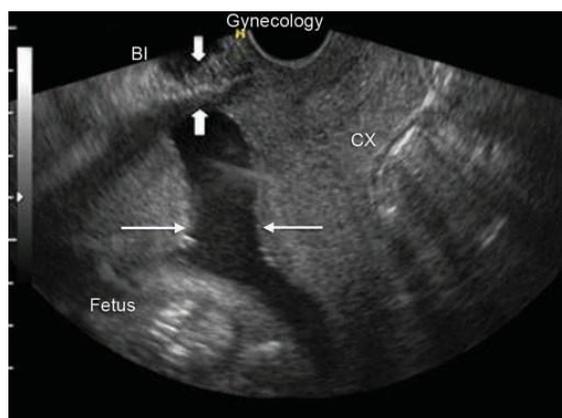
Transvaginal ultrasound of a pregnant (24 weeks) demonstrated a fenestration within a uterine scar (large arrows). Thinning of the myometrium over the CD scar defect (small arrows) (24).
